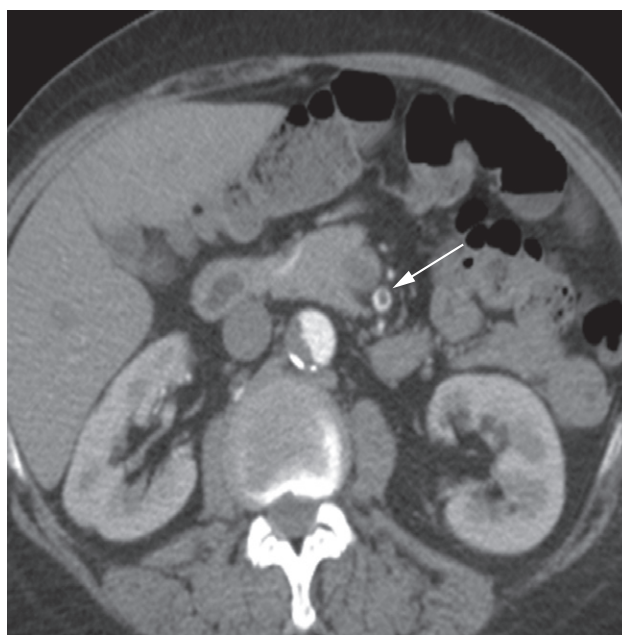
Axial CT showing a thrombus in the superior mesenteric artery (arrow).
